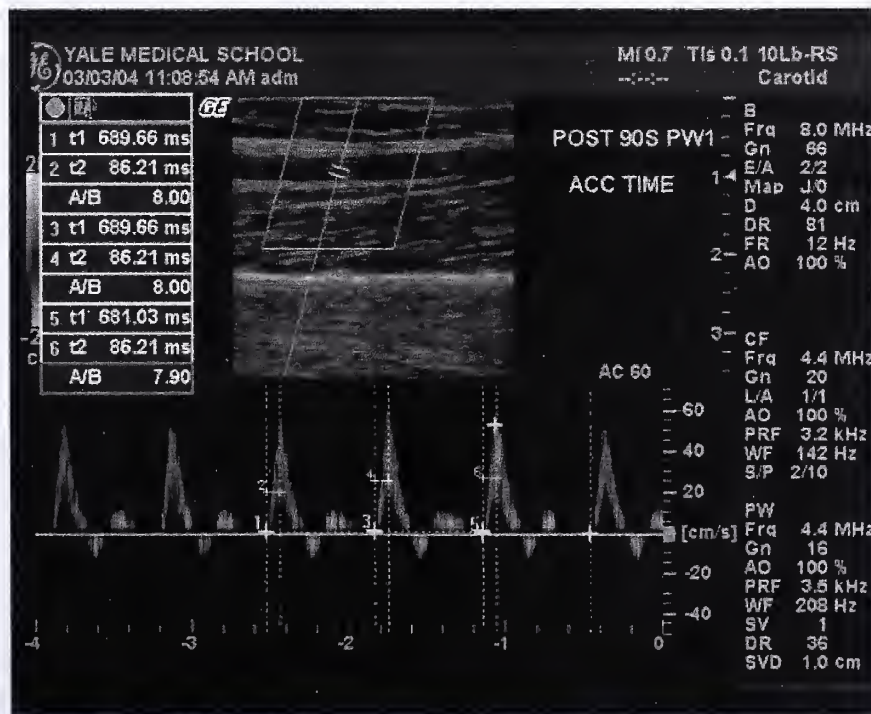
Example of Doppler Waveform Data
